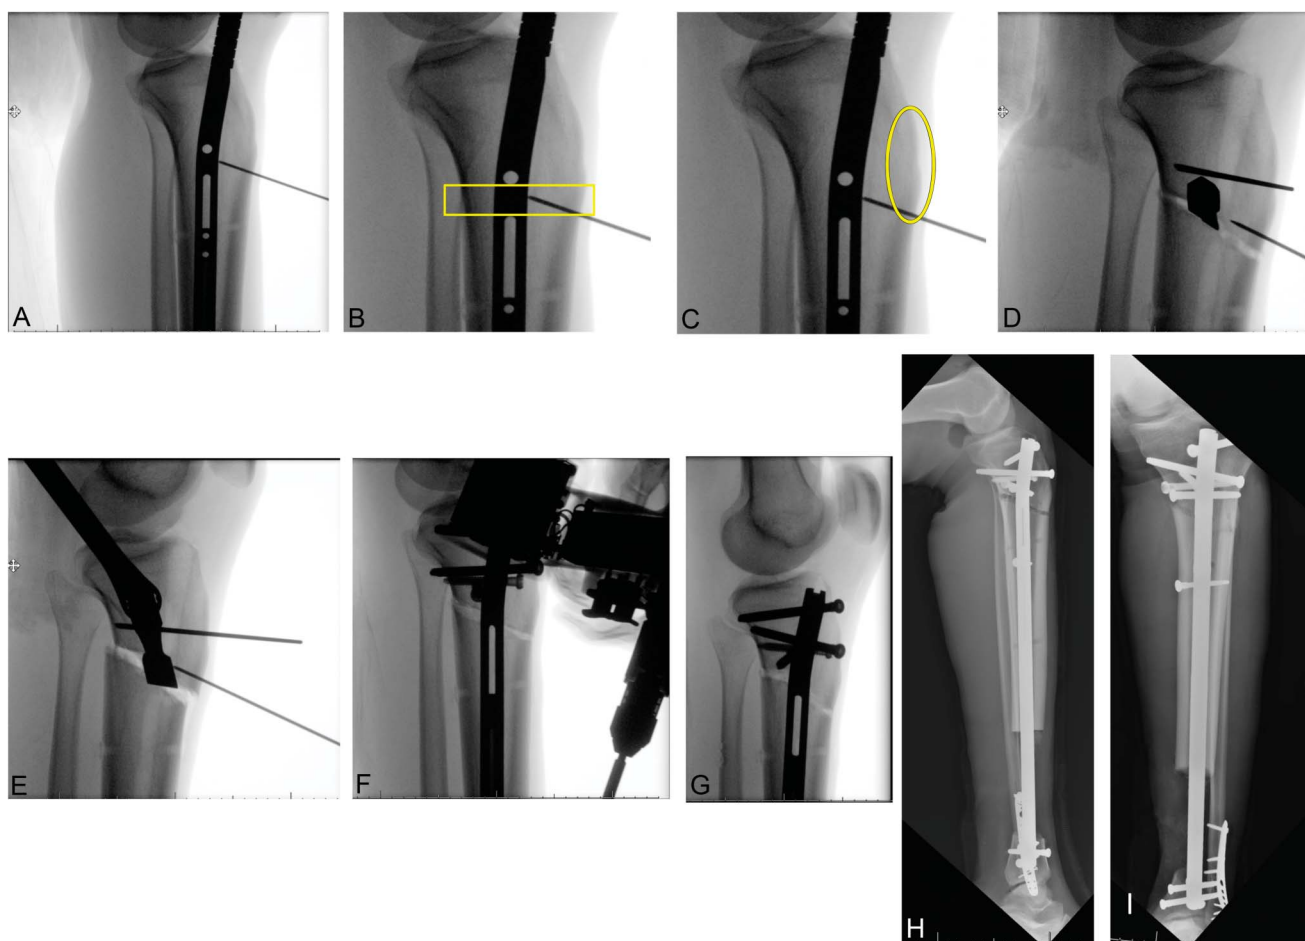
A, The nail is inserted and set to an optimal depth distally. The site of the osteotomy is marked in this case using a Steinmann pin. B, It is essential that the osteotomy be made in the tight 1 cm interval between the top of the screw slot and the bottom of the locking screw hole if we are to assure 10 cm of stroke length and use of the most distal locking screw in the proximal cluster. C, The osteotomy must also avoid the tibial tuberosity. Osteotomies performed through the tibial tuberosity have the potential to result in fibers from the patellar tendon remaining attached to the transport segment, which must be avoided. D, E, The osteotomy is made obliquely from anterior to posterior, in this case, to avoid the patellar tendon but optimize the amount of bone available proximal to the nail. The osteotomy is completed by using a 13 mm wrench to rotate the handle of an Ilizarov osteotome. F, G, Lateral view of osteotomy site while compression is being applied to test the nail and following testing with compression of 4 mm. H, I, Initial postoperative radiographs showing the final construct and excellent apposition of the osteotomy site.
